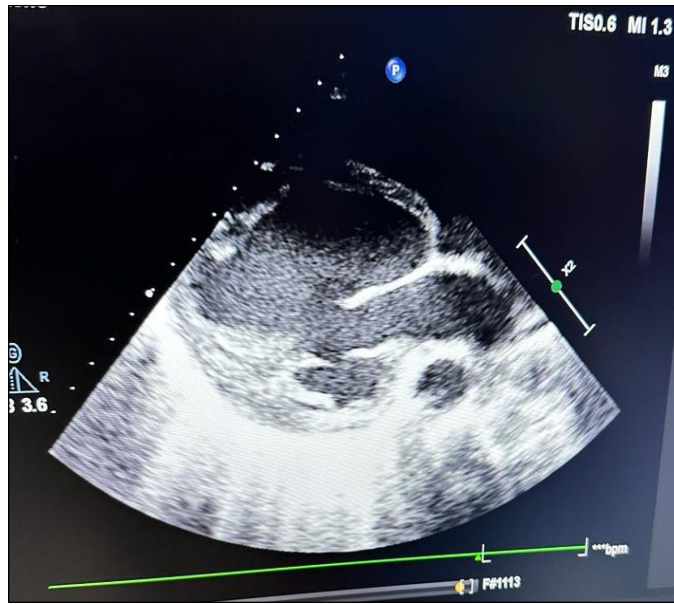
Echocardiography of same patient showing dilated LV
